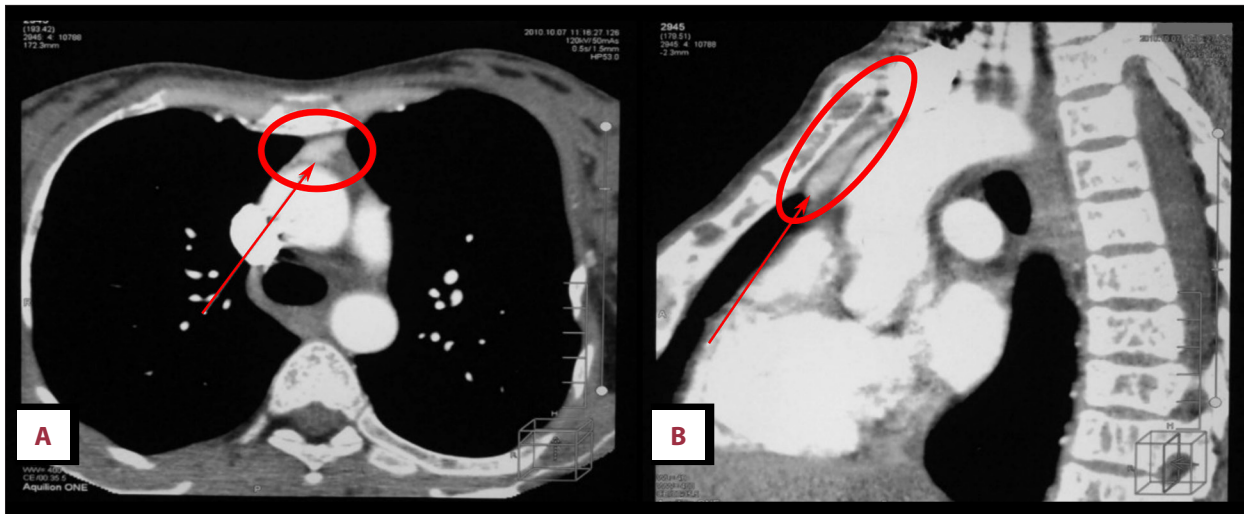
A case of pregnancy complicated by primary hyperparathyroidism: Contrast-enhanced computed tomography (CT) images of the ectopic parathyroid gland. (A) Contrast-enhanced computed tomography (CT) axial image of the ectopic parathyroid. (B) Contrast-enhanced CT sagittal image of the ectopic parathyroid (shown by an arrow).
